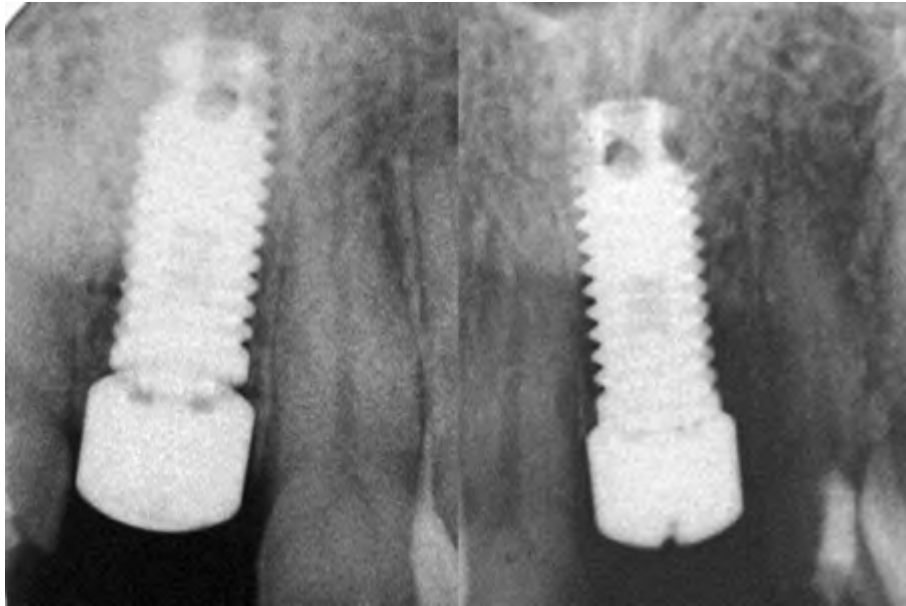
The left periapical radiograph demonstrates that the healing abutment was not seated accurately and completely onto the implant restorative platform. The healing abutment was removed from the implant, the soft and hard tissue interferences were removed with profiling instruments, and the healing abutment was resealed accurately and completely onto the implant restorative platform. Accurate seating was demonstrated on the right periapical radiograph.
